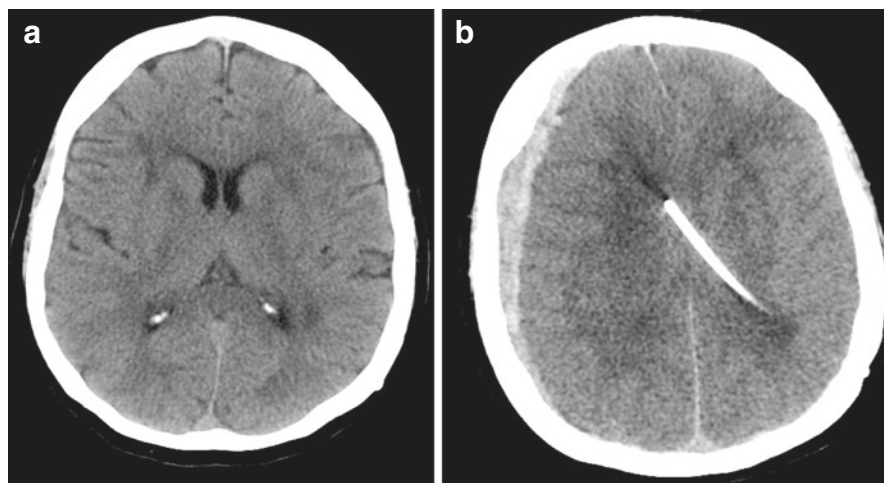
Axial non-contrast CT of a 63-year-old male with moderate ventricles prior to left parietal shunt insertion (a). Interval development of a right acute subdural hematoma after cerebrospinal fluid overdrainage resulting in slit ventricles (b)
